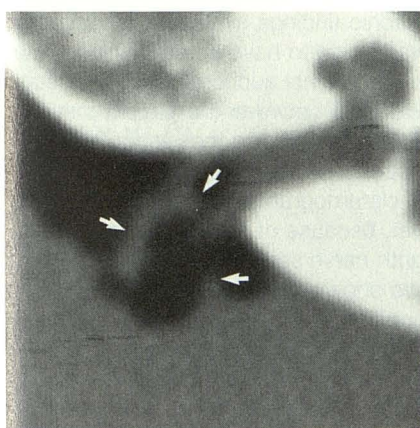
Case 12: Left air CT cisternogram shows vascular loop (arrows) crossing neurovascular bundle as it emerges from internal auditory canal.
